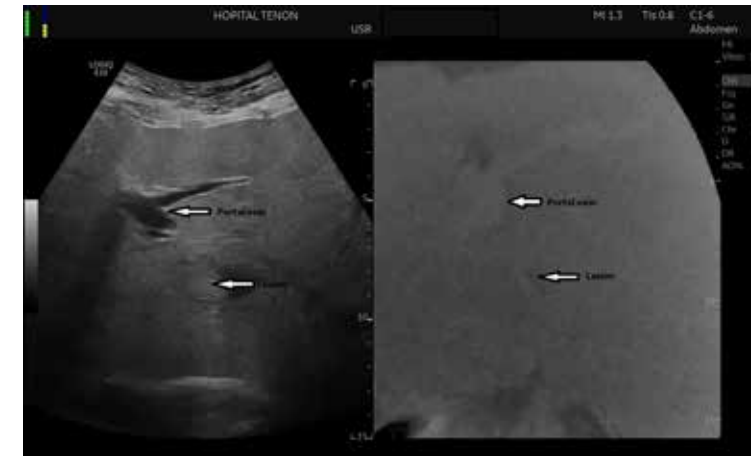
Example of CBCT/ultrasound fusion with automatic registration.
